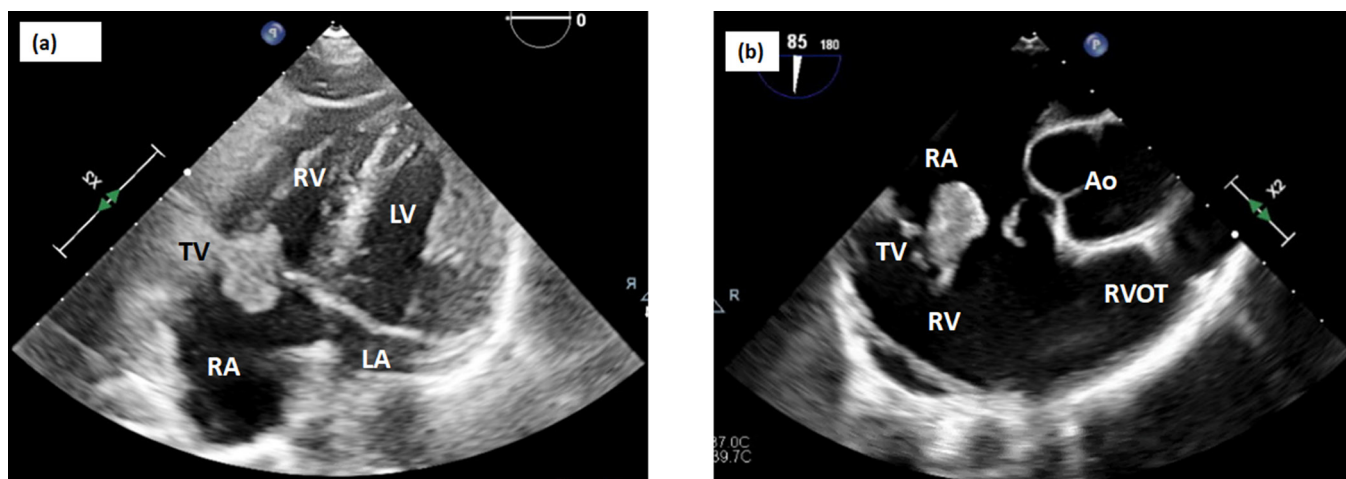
Transthoracic and transesophageal echocardiogram images. (a) Apical four chamber view and (b) right ventricular inflow–outflow view showing large (~1.8×2 cm) tricuspid valve mobile vegetation attached to the atrial aspect of the anterior tricuspid leaflet. Mass enters the RV during diastole and obstructs tricuspid leaflet closure during systole. LV, left ventricle; RV, right ventricle; LA, left atrium; RA, right atrium; TV, tricuspid valve; Ao, aorta; RVOT, right ventricular outflow tract
